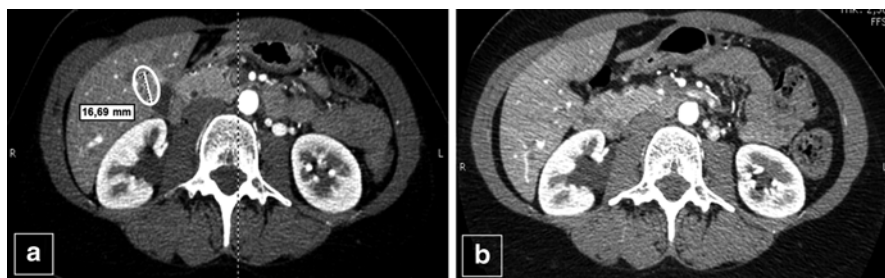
(Panel a) CT scan of the hepatic metastases, with the largest one located very close to the gallbladder and measuring 17 mm in September 2012. (Panel b) Patient's liver CT scan 12 months after metastasectomy in 2014: no recurrence of the largest lesion was visible
